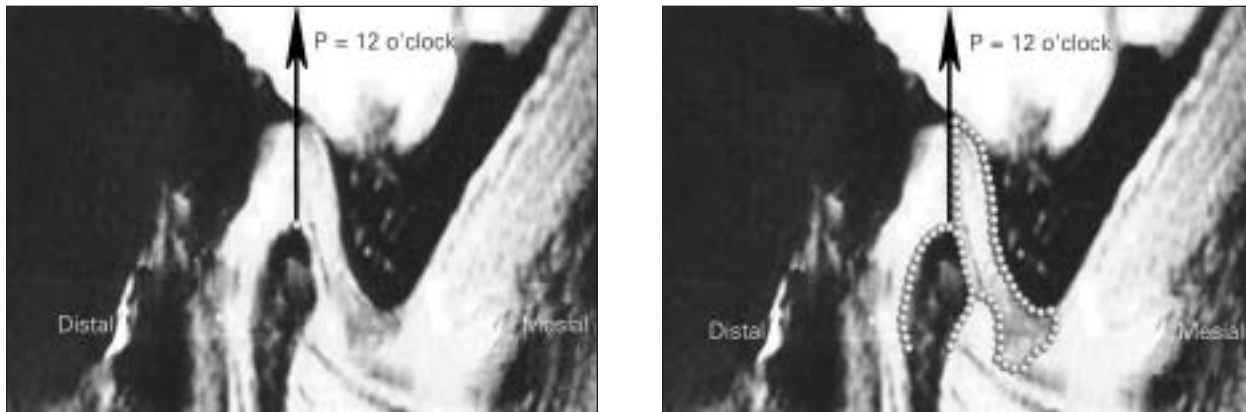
MRI of posttreatment disc recapture. The P ray represents the posterior band of the disc and is superimposed on the 12 o'clock reference plane. In other words, the disc was recaptured to the normal 12 o'clock position; ie, the disc was recaptured above the condylar head. Note the increase in disc length after occlusal splint therapy. In the figure on the right, the outline of mandibular condyle and the articular disc is marked.
